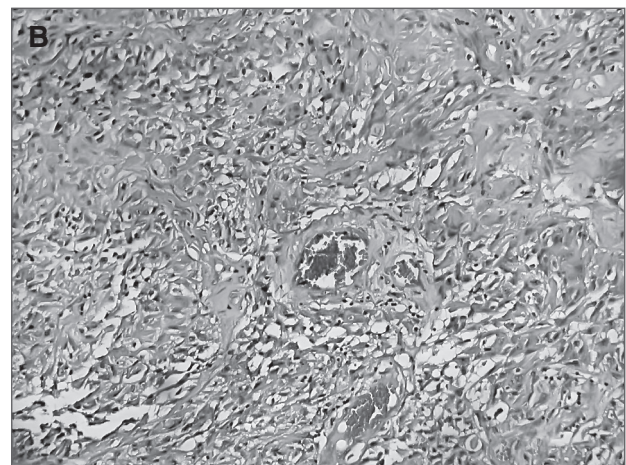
A: Magnetic resonance image showing a solid mass located in the right frontal lobe. B: Routine section shows a typical infiltrating glioblastoma multiforme.
